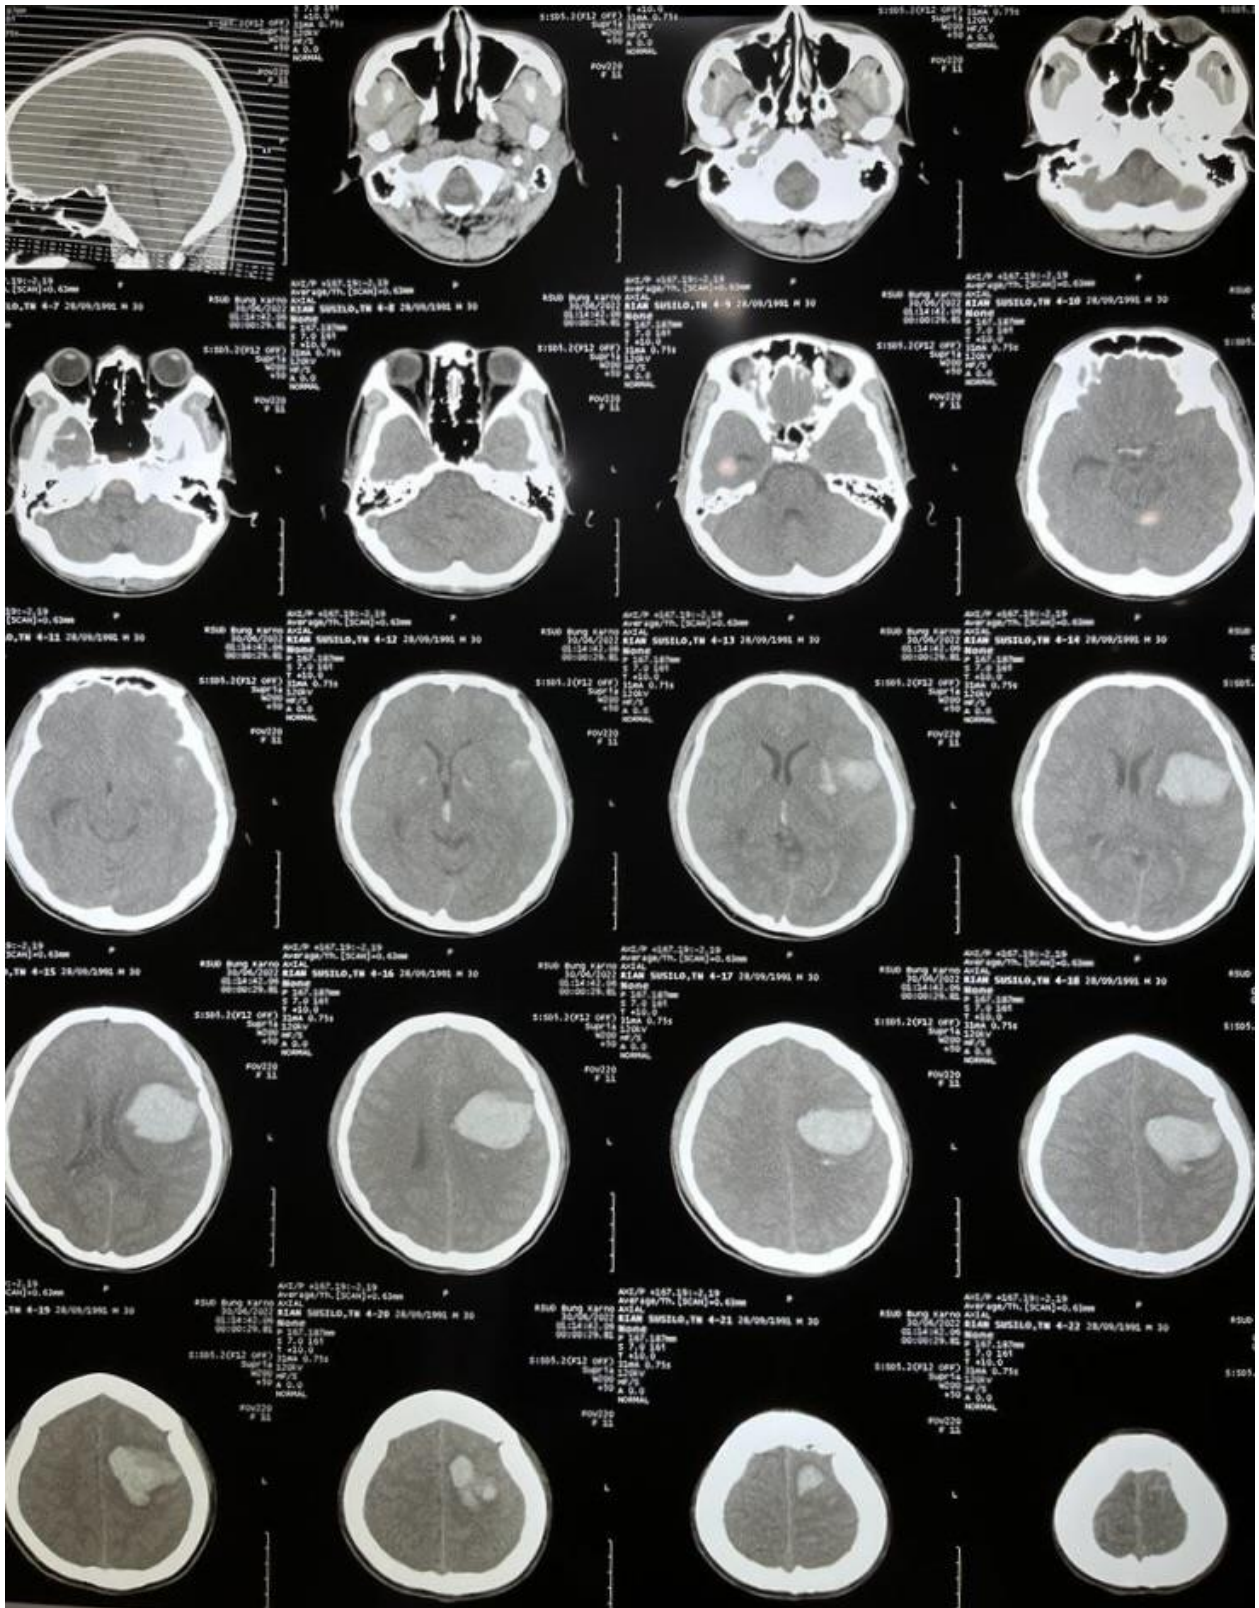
Non-contrast CT scan showed intracerebral haemorrhage in the left temporoparietal region.
